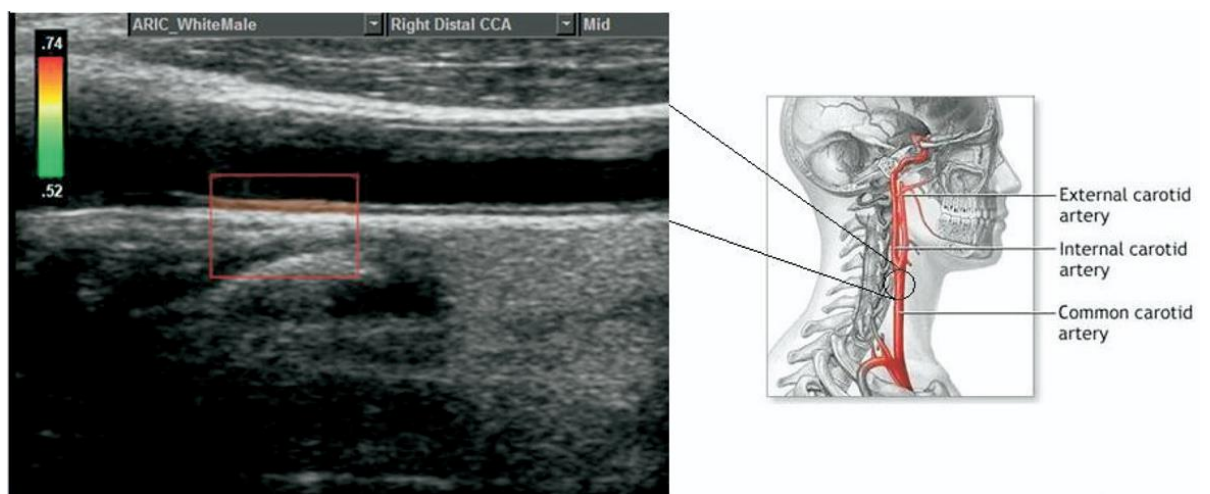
Image of the carotid artery obtained using ultrasound in carotid IMT (Adapted from Hurst et al., 2007).
